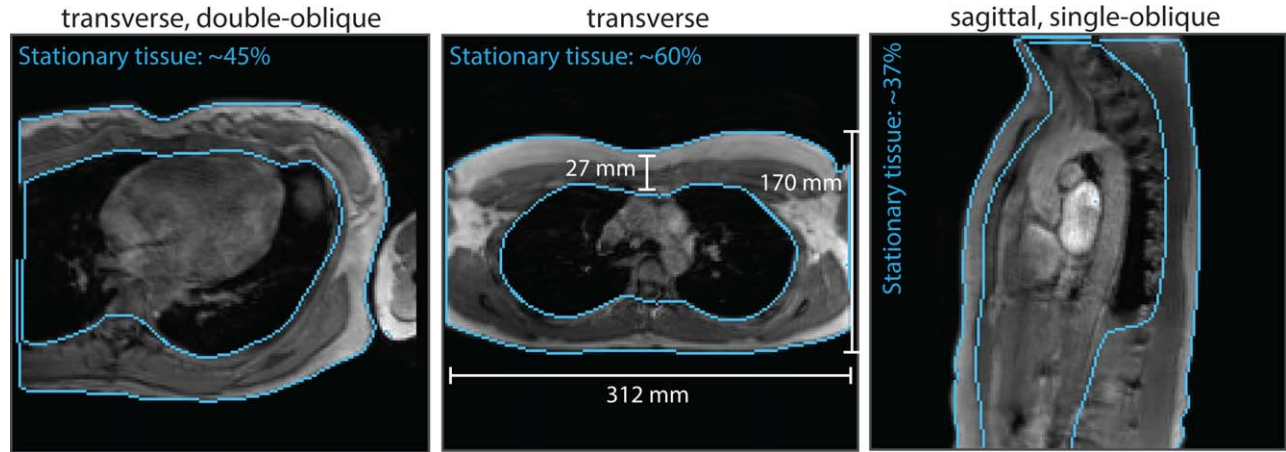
Exemplary MRI data acquired in a double-oblique transverse, transverse, and single-oblique sagittal view. The edges of the stationary tissue used for correction of the background phase error by linear regression are indicated in light blue and the amount of stationary tissue is stated.
